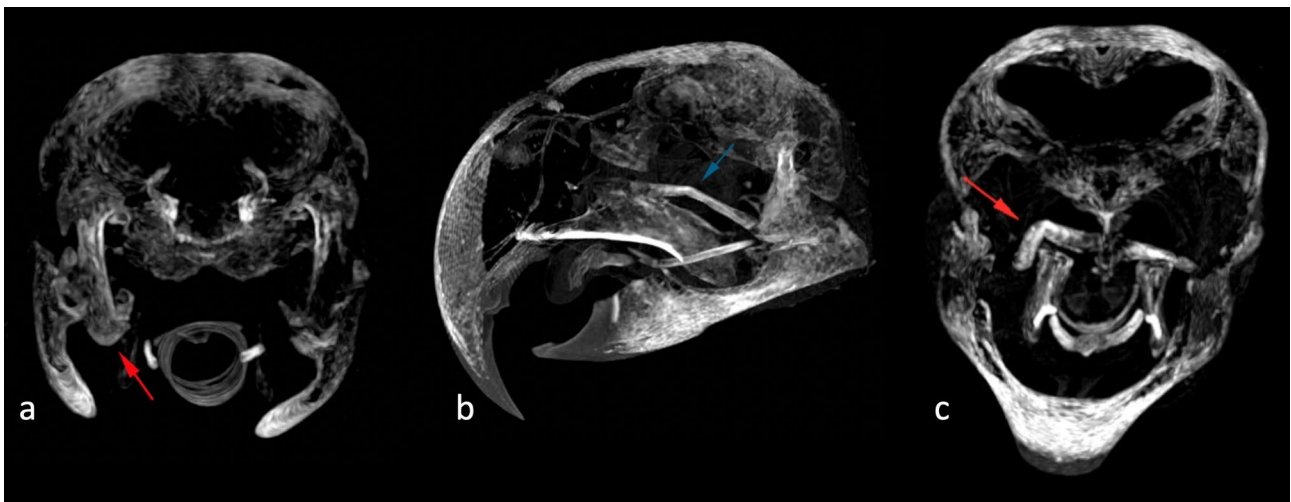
(a) Transverse CT section in maximal intensity projection (MIP). Right quadrato-mandibular rostroventral luxation (red arrow). (b) Parasagittal CT section in MIP. Incomplete fracture of the right pterygoid bone (blue arrow). (c) Transverse CT section in MIP. Incomplete fracture of the right pterygoid bone (red arrow)
